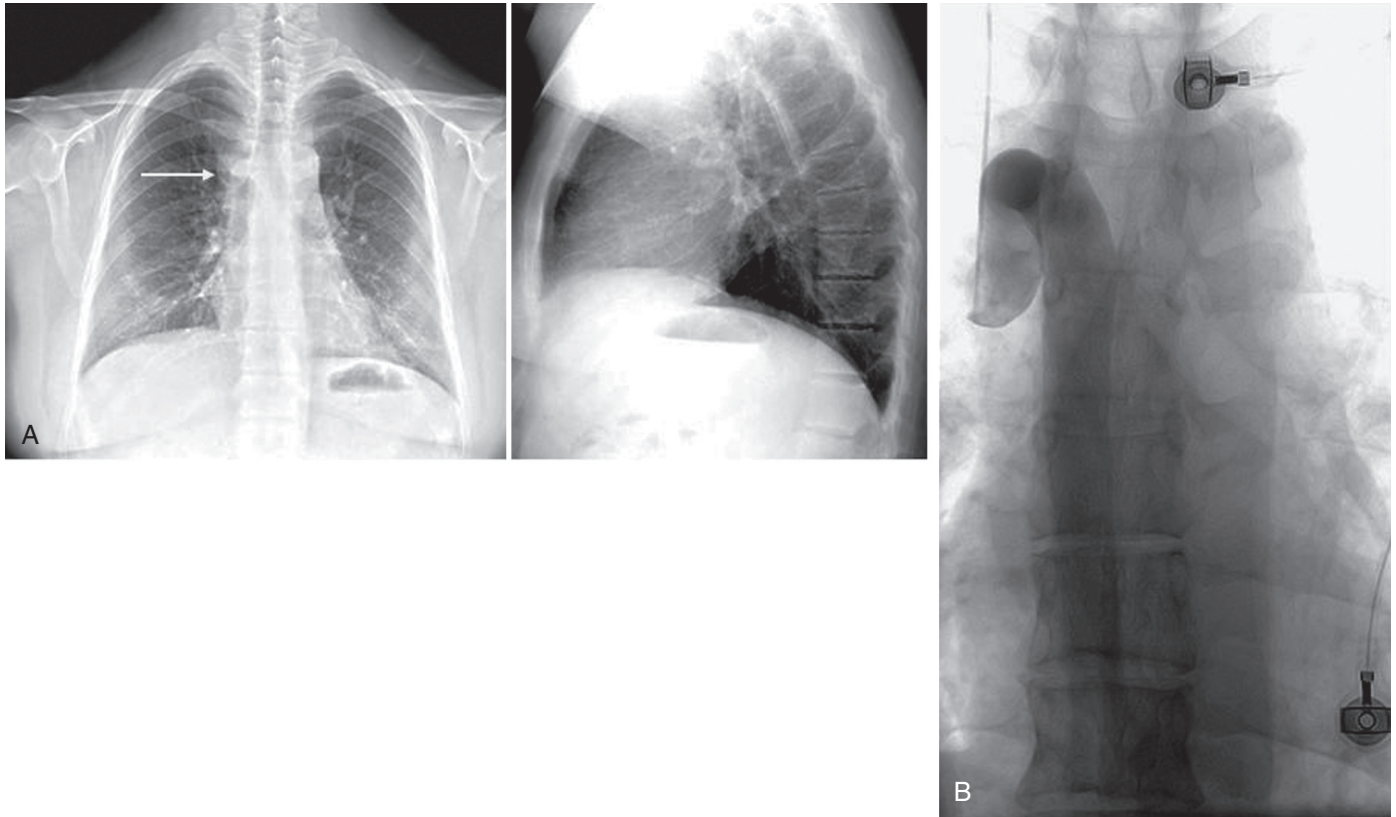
FIGURE e15-3 Radiographs of a 39-year-old renal transplant patient. A, Normal PA and lateral images, except for prominence in the azygos vein region (arrow). B, Right innominate venogram demonstrating an occluded SVC and markedly enlarged azygos vein draining below the diaphragm.
